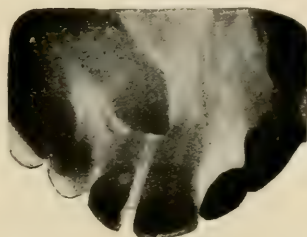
The negative for this radiograph was made at the same time with Fig. 386, the film and the bromide paper being enclosed in the same packet.
